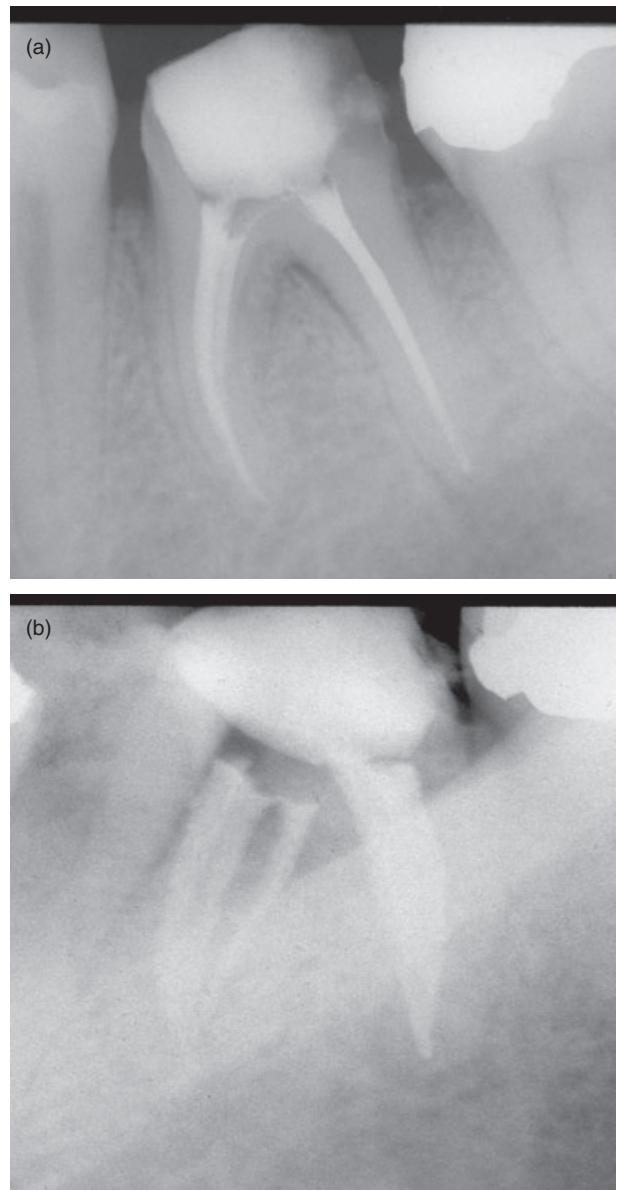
(a) Ortho-radial postoperative radiograph. (b) Postoperative radiograph taken from distal aspect.
